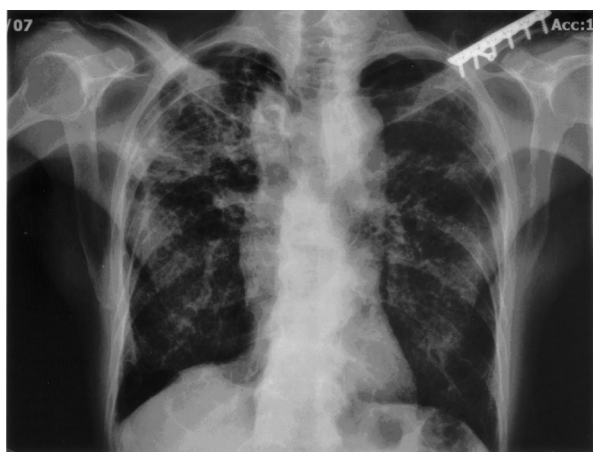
Chest radiograph showing bilateral fibrotic and bronchiectatic changes. Emphysema is noted in both lungs.
